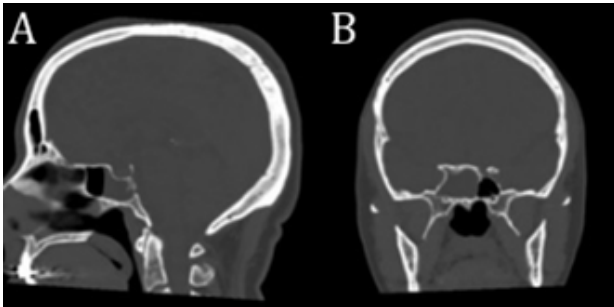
CT head (A) Sagittal view (B) Coronal view showing: Focal bony defect at the posterior wall of sphenoid sinus with partial opacification of the sinus, showing air-fluid level suspicious for CSF leakage with bony erosions and small cyst.
